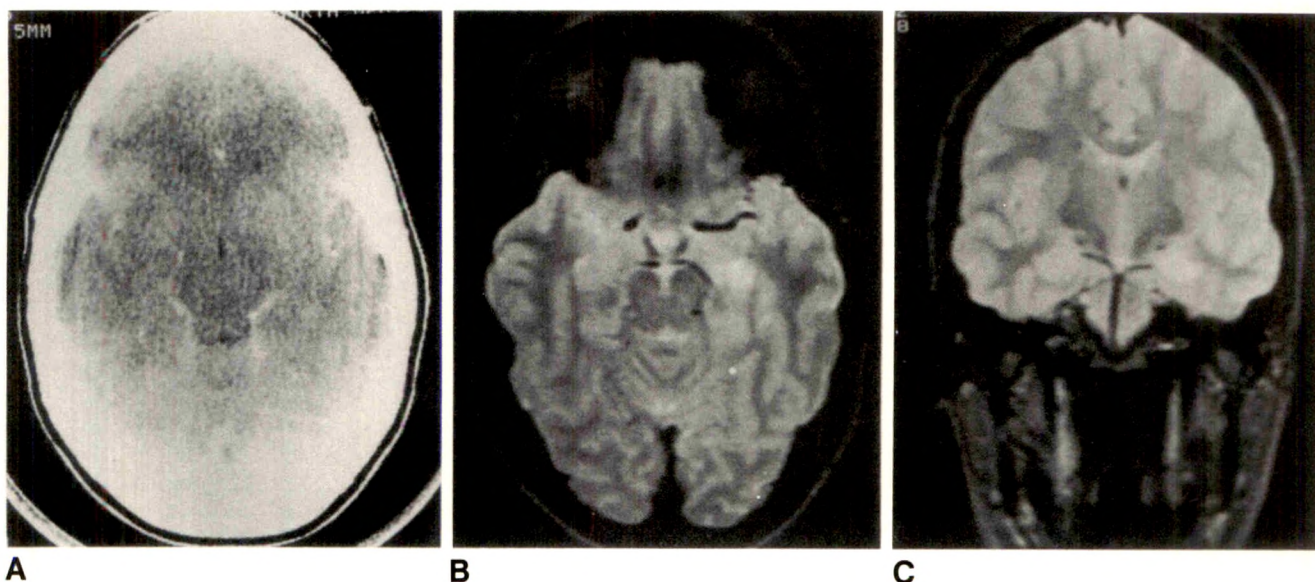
Case 1: 17-year-old woman with complex partial seizures for 14 years. Scalp EEG: left spike focus. Depth electrodes: left temporal focus. CT negative; MR positive.
